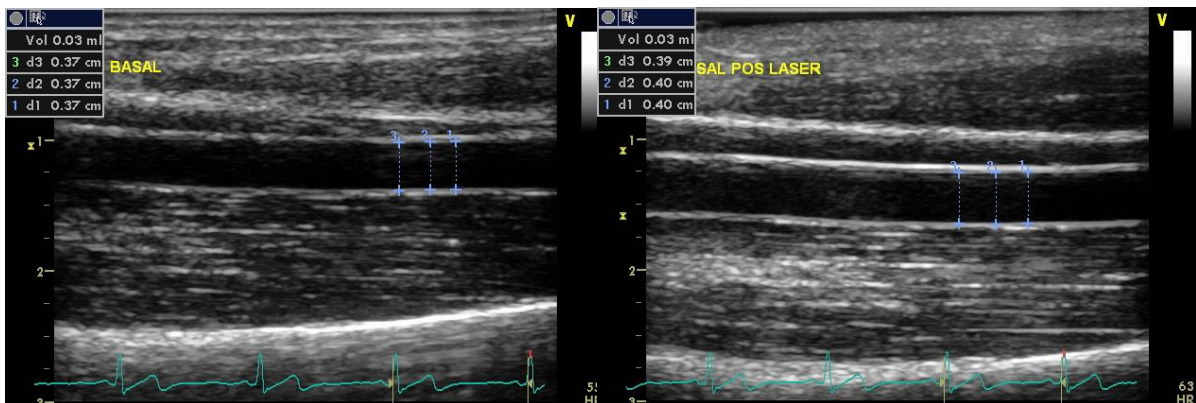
The measurement of endothelial function (%FMD) by ultrasound images that were acquired before (baseline evaluation: first image) and immediately after the cuff disinflation (reactive hyperemia evaluation: second image).
